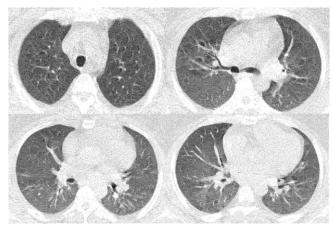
Post-treatment thorax CT
